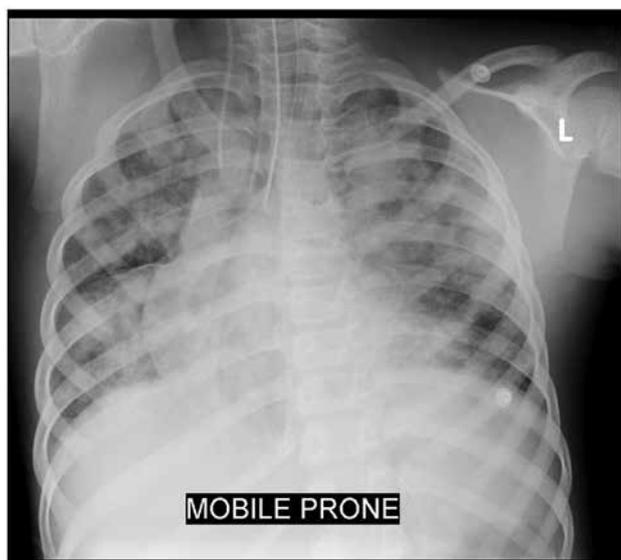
Follow-up chest radiograph.
